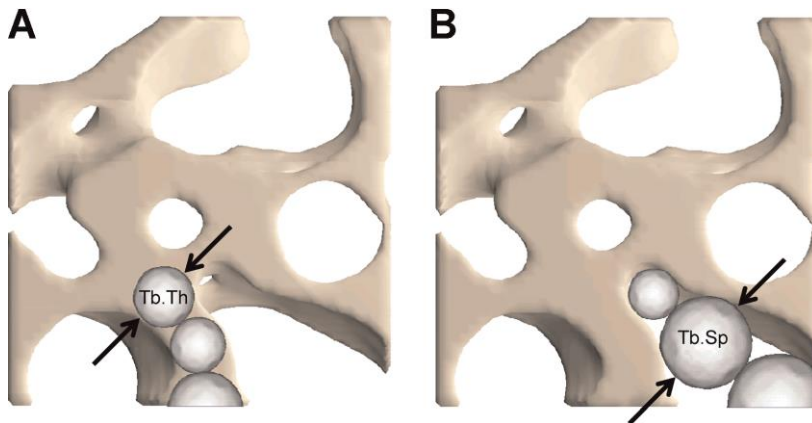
Method used for Calculating μ CT Parameters. (A) trabecular thickness (Tb.Th) and (B) separation (Tb.Sp). This direct three-dimensional method uses sphere fitting to obtain object thickness or separation. Image obtained with permission from (55).
